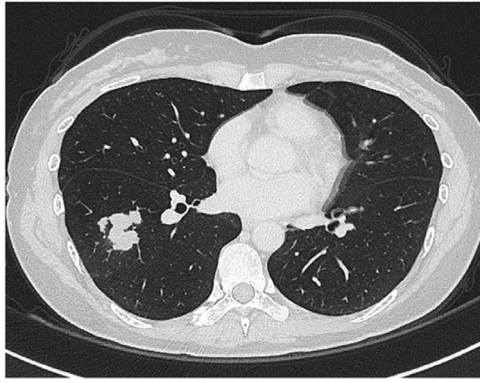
Chest computed tomography revealed nodules on the right lung, leading to a diagnosis of primary lung cancer.
